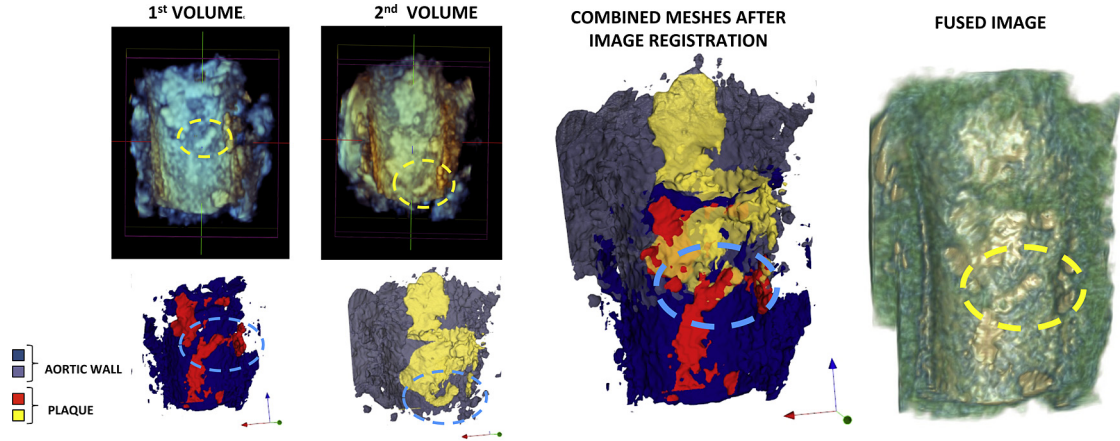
Example of the clinical validation procedure. Top left: Two contiguous 3-D transesophageal echocardiographic data sets in which a detail of the same plaque is highlighted with a *yellow circle*. Bottom left: Corresponding result, as 3-D mesh, of plaque segmentation obtained with custom software, with a detail of the same plaque highlighted with a *blue circle*. Right: Result of the image registration, defined using the original 3-D transesophageal echocardiographic data, applied to the 3-D meshes and correspondent combined volume rendering. The overlap of the two corresponding plaque details is highlighted.
